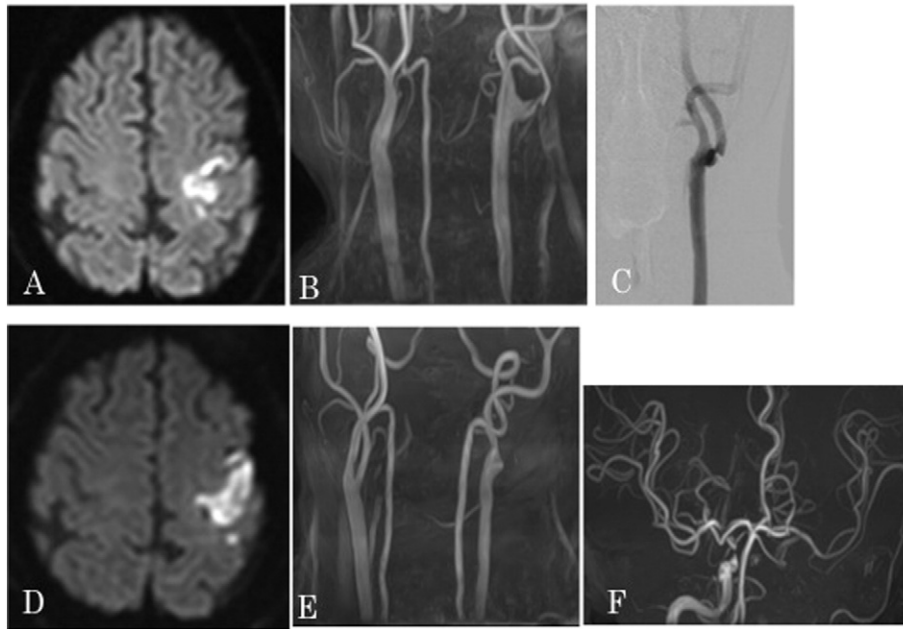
Radiographic findings for Case 1. A: on admission, diffusion-weighted MRI detected a cerebral infarction in the left cerebral hemisphere. B: MRA demonstrated left cervical ICA stenosis. C: left carotid angiography demonstrated cervical CA stenosis. D: 20 h after CEA, diffusion-weighted imaging showed slight expansion of the cerebral infarction from the time of admission. E,F: cervical and cranial MRA revealed right ICA occlusion and cross-flow from the left ICA through the anterior communicating artery.
